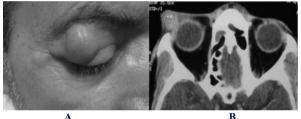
(a) Clinical presentation of tubercular orbital mass presenting clinically as orbital cellulitis (left side) (b) CT scan-axial view showing heterogenous exctraconal orbital mass resulting inoutward protrusion of left eye.
